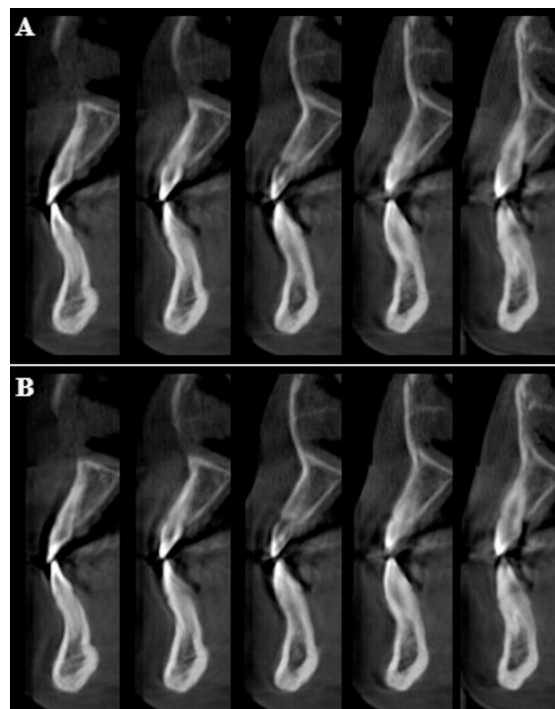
It is known that the noise varies depending on the section thickness. Cross-sectional CBCT images show noise variation between images with slice thickness of 0.4 mm in A and slice thickness of 5.20 mm in B.
